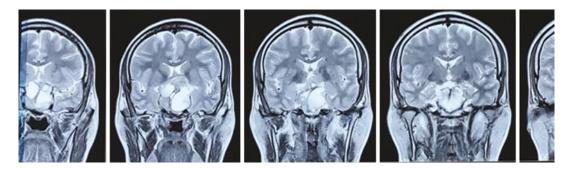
MRI brain coronal section showing a pituitary tumour
